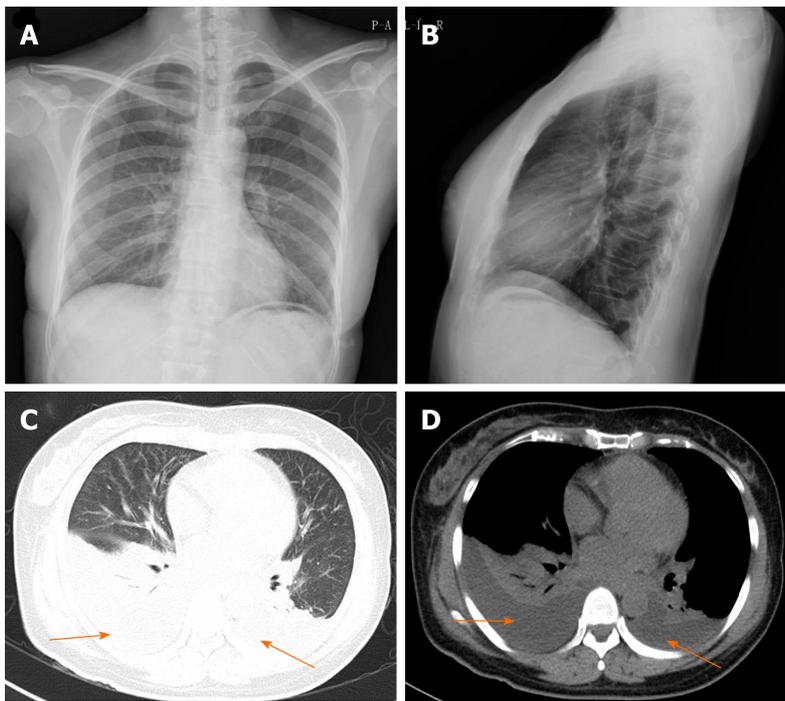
Preoperative chest X-ray films and chest computed tomography of postoperative day 2. A and B: Preoperative frontal (A) and lateral (B) chest films show a normal chest; C and D: Postoperative high-resolution computed tomography shows bilateral small to moderate effusion (orange arrow).
